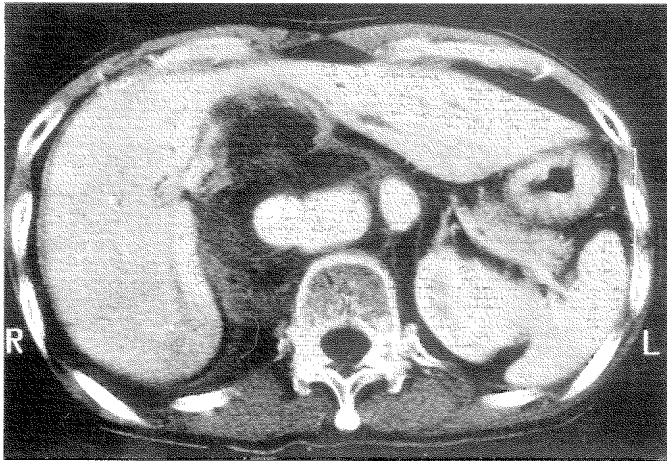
Preoperative computed tomography of the abdomen showing a mycotic paravisceral aortic aneurysm.
